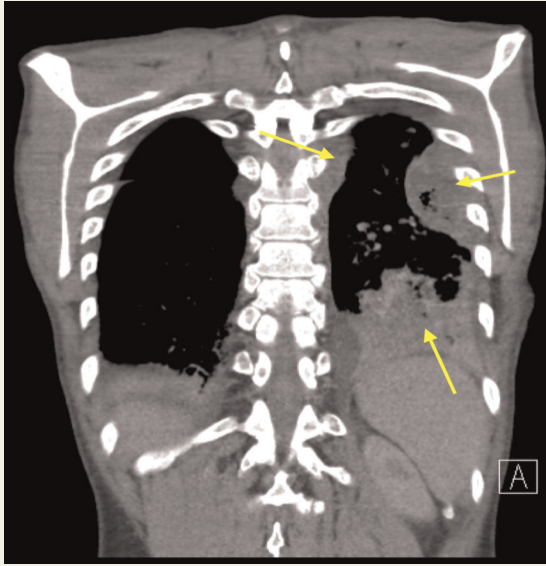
Post contrast CT showing loculated subpleural, collection extending along the rib with paravertebral collection.
